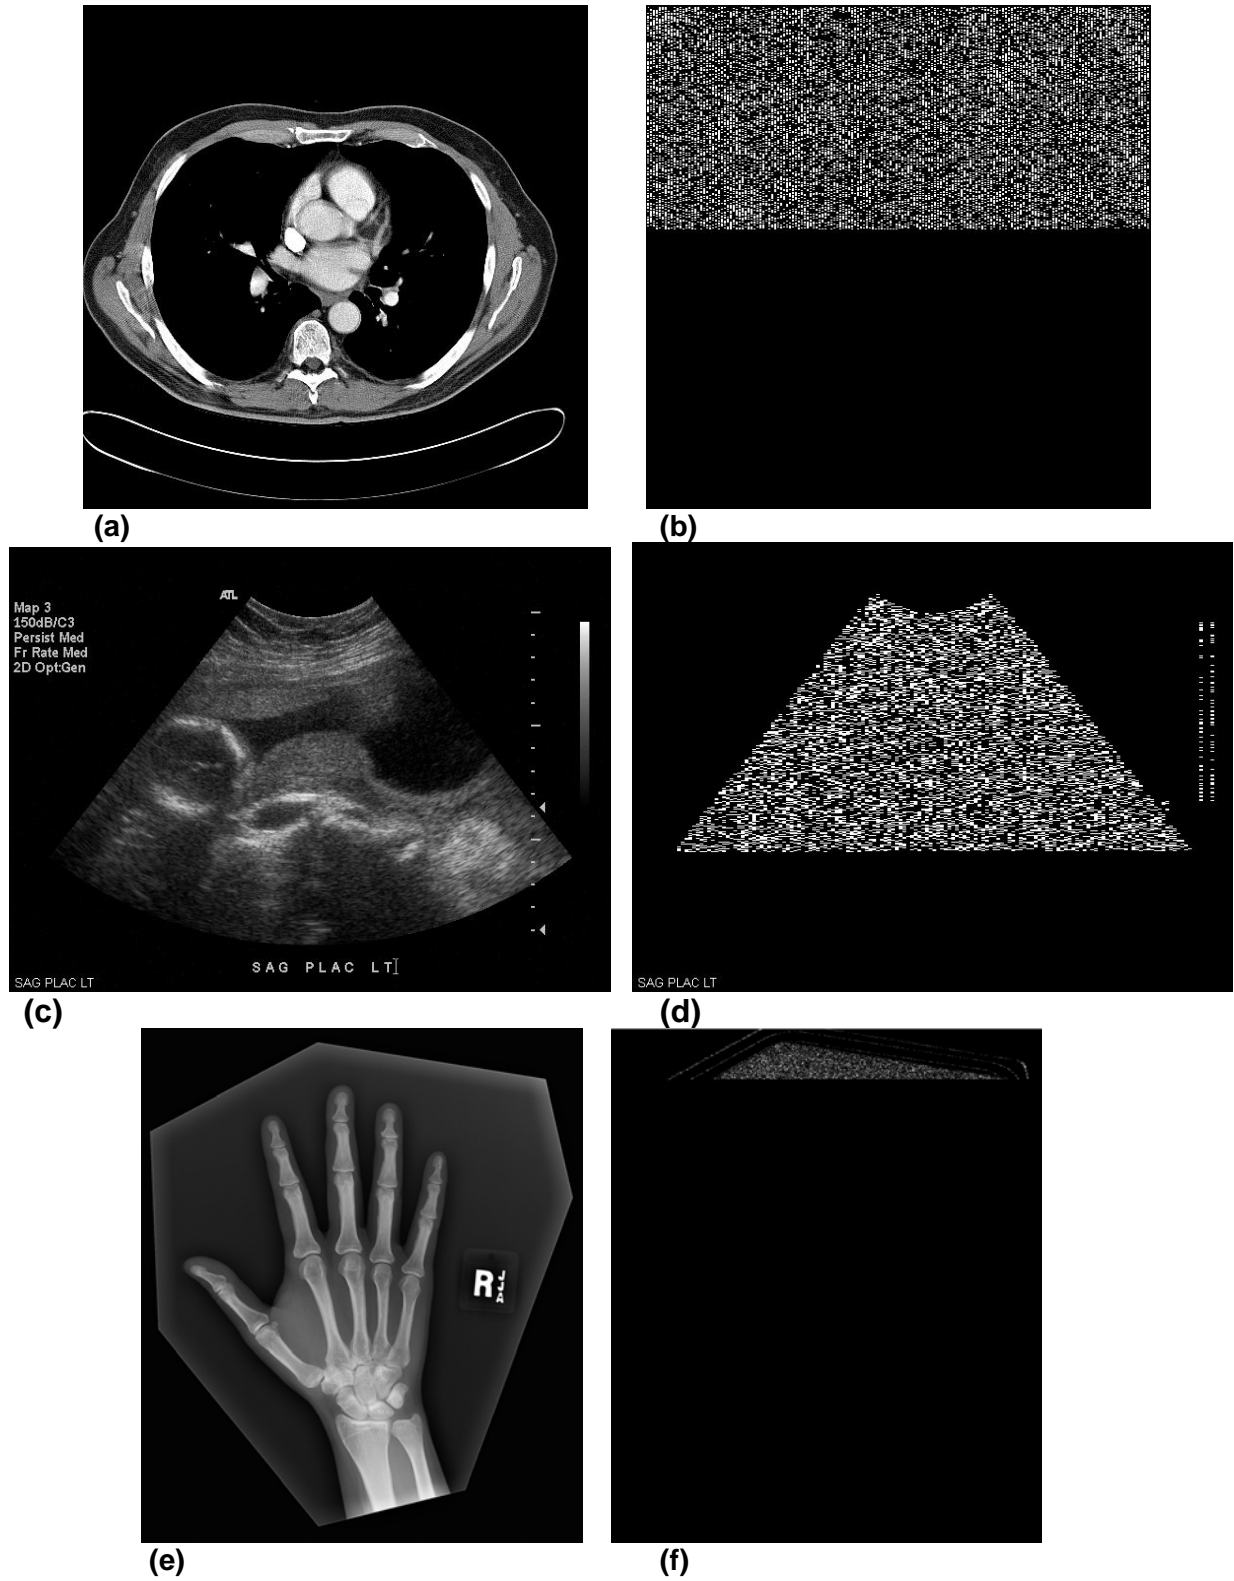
Example of the 2-D LDSERS results. (a) CT chest image with signature embedded; (b) The subtracted image between the original CT chest image and (a) showing where the digital signature is embedded; (c) US OBGYN image with signature embedded; (d) The subtracted image between the original US image and (c); (e) CR hand image with signature embedded; (f) The subtracted image between the original CR image and (e).
